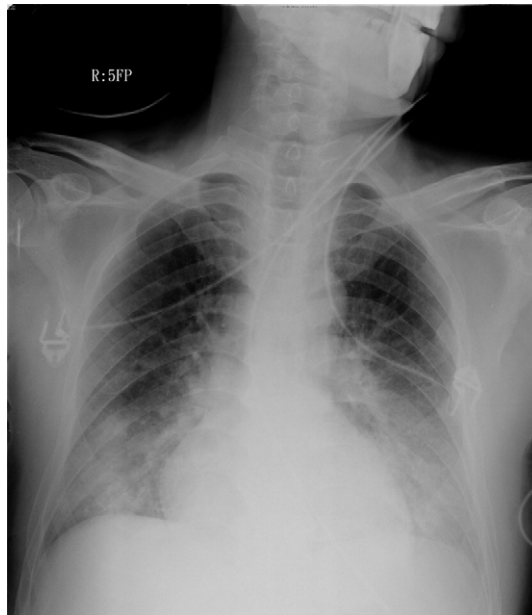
Chest x-ray showed marked patchy bilateral lung infiltrates.
